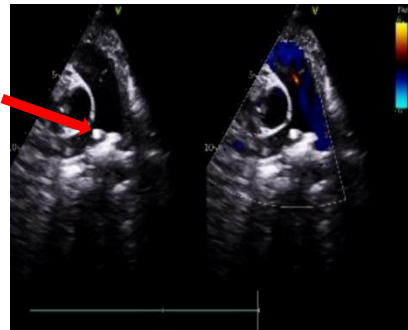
Echocardiography showing the tip of the catheter migrated to the level of the right pulmonary artery.
